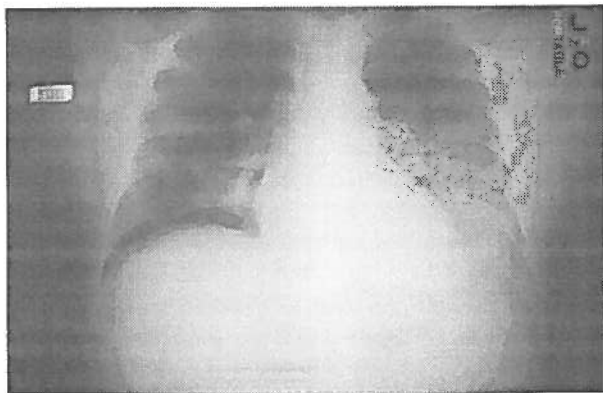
Follow-up chest radiograph shows worsening of the left lower lobe infiltrate as assessed by further lobe consolidation and development of a small pleural effusion.
